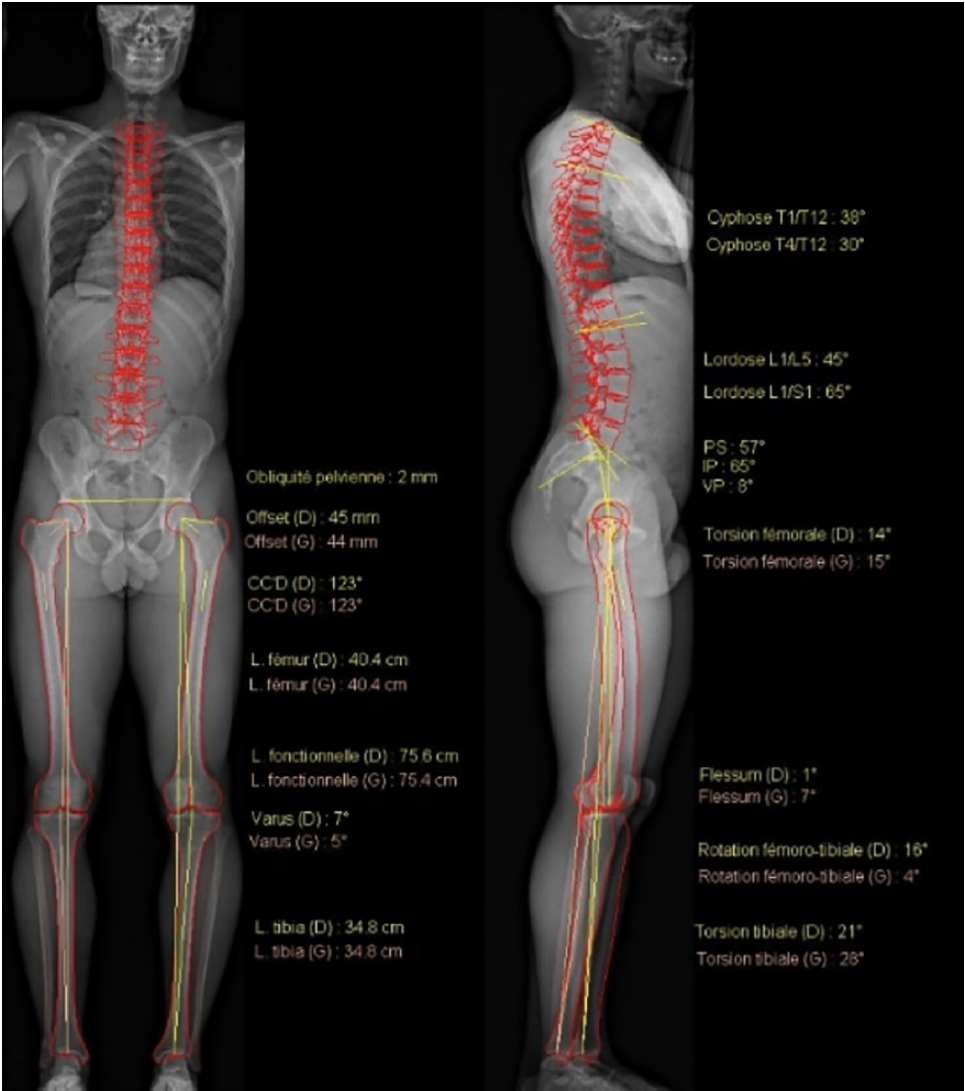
Full spine contouring on paired frontal and lateral views on an EOS radiograph, with appropriate manually placed landmarks and automatically provided angles.
